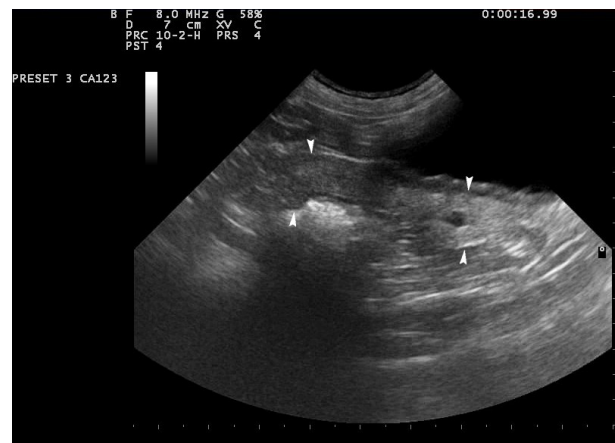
Ultrasonographic view of a reduced number of endometrial cysts after the third pregnancy of the bitch
